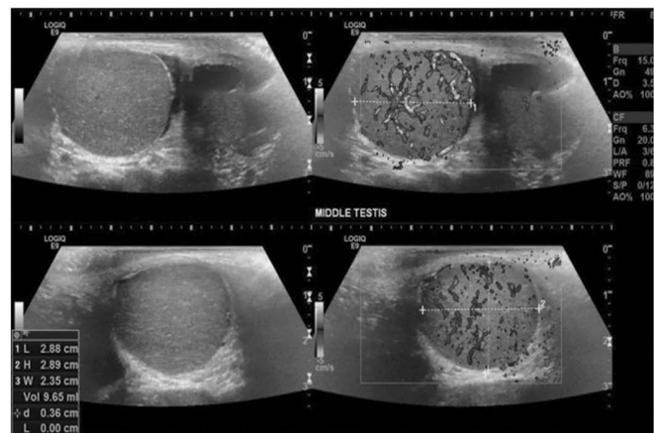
Pre-operative ultrasound showing left accessory testis .
